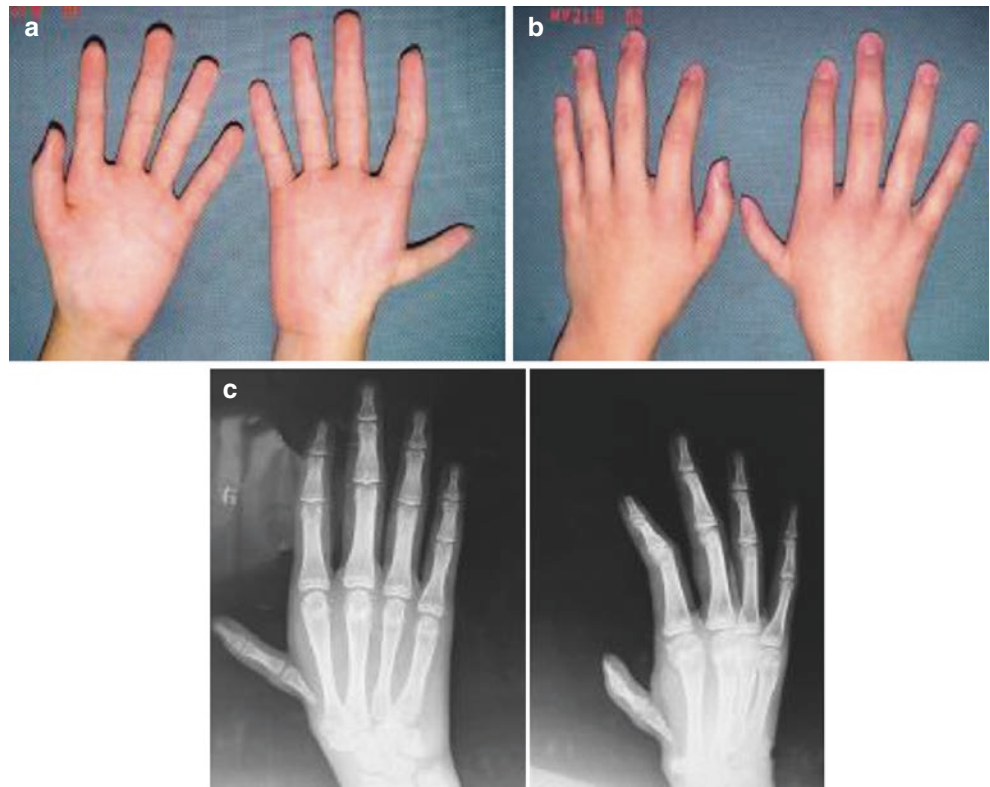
Case four: type IIIc thumb dysplasia of the left hand. (a) Hand appearance. (b, c) X-ray findings
